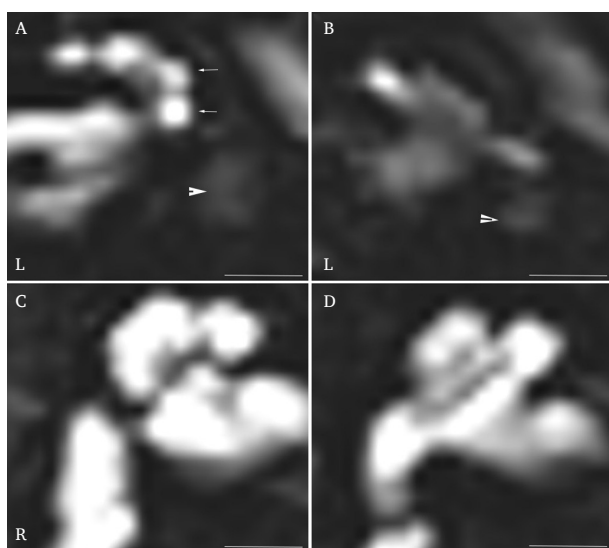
MRI of T2-sampling perfection with application-optimized contrasts via a flip angle evolution (SPACE) sequence of the inner ear 4 d after round window repair. Slight refilling of the perilymph in the left cochlea (arrows in A) and vestibule (arrowheads in A and B), which has not reached the same level as the right ear (C and D). Scale bar = 3.0 mm.
